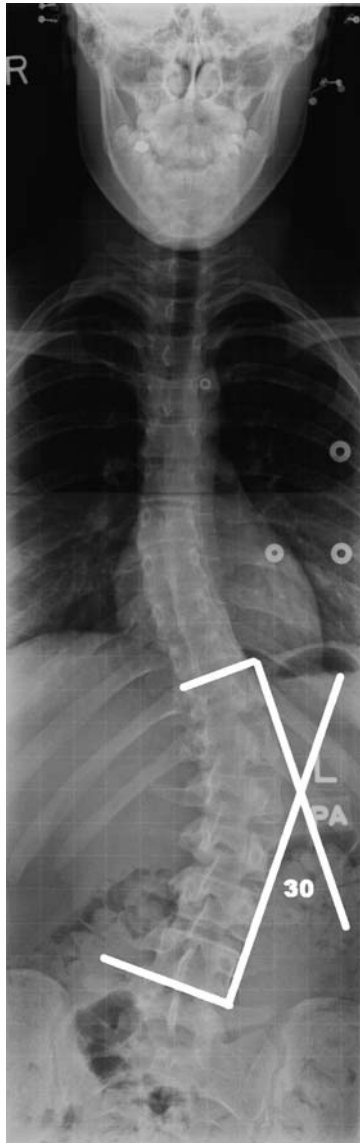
The Cobb angle is the measurement used for evaluation of curves in scoliosis on a PA radiograph. It is measured as the angle between the two perpendicular lines drawn from parallel lines running through the most tilted superior and inferior endplates.
